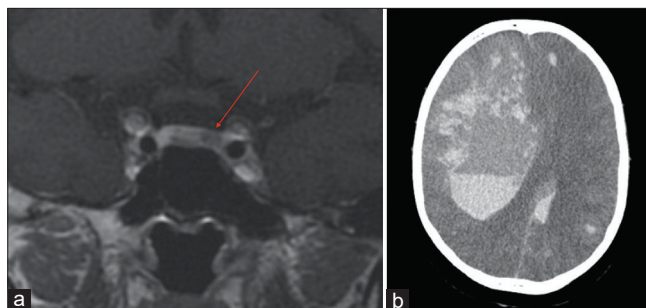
(a) Coronal sellar MRI - red arrow shows a left microadenoma. (b) Postoperative cranial computed tomography exhibiting a large intracranial hemorrhage - right frontal lobe. There are multiple other frontoparietal hemorrhagic foci and signs of subfalcine herniation.
